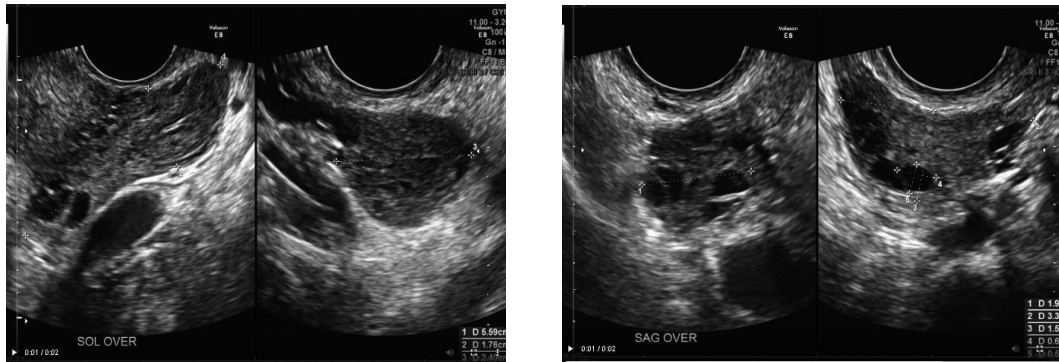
Ultrasound imaging of polycystic ovary
